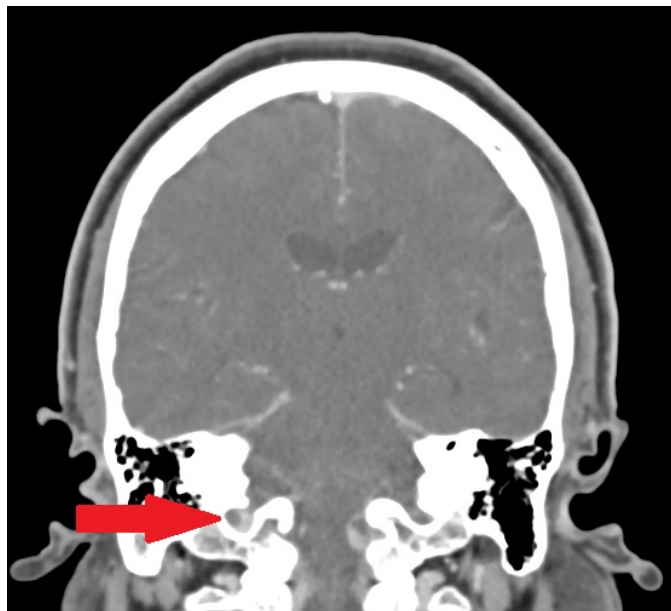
CT venography of the head showing a nonocclusive thrombus in the right sigmoid sinus.
